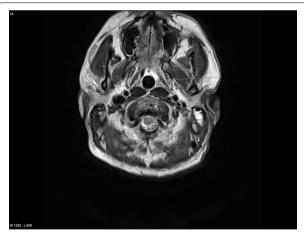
Cross-sectional view of magnetic resonance imaging demonstrating the gag (*arrow*)
